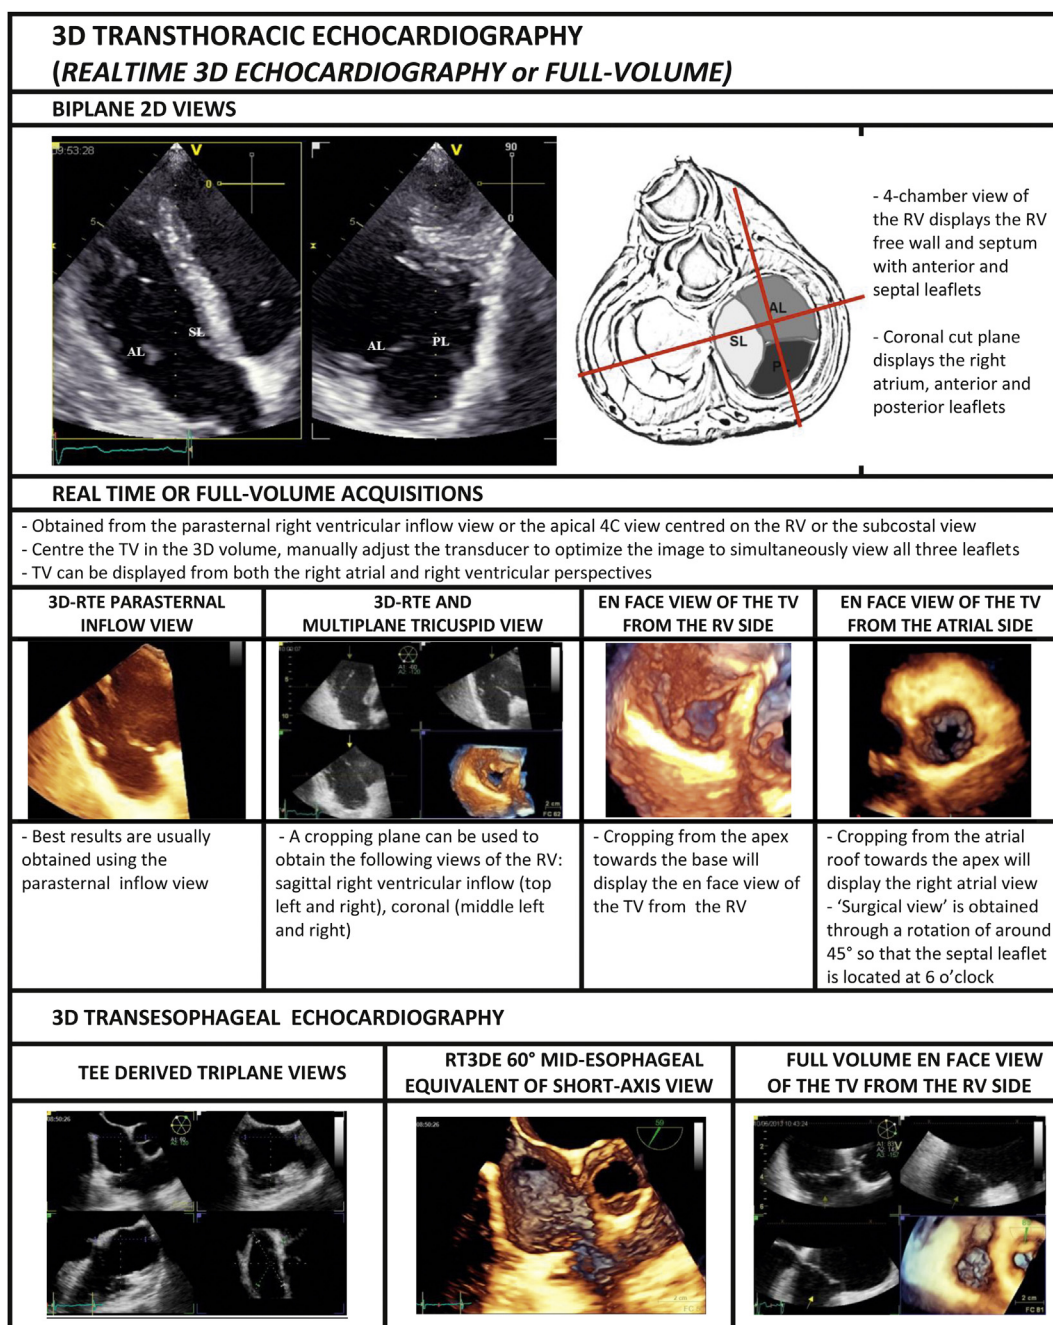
Three-dimensional (3D) imaging of the tricuspid valve (TV). RV: right ventricle; TV: tricuspid valve; AL: anterior leaflet; PL: posterior leaflet; SL: septal leaflet; RT3DE: real-time 3D echocardiography.
